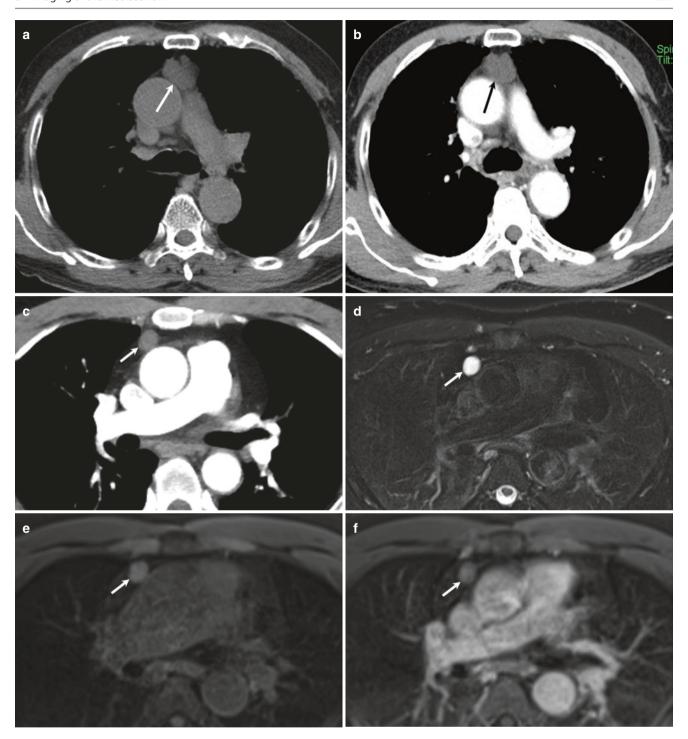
(a, b) Unenhanced and contrast-enhanced CT images show a thymic cyst (arrow) in typical prevascular space location without any enhancement. High-density thymic cyst in another patient. (c) Axial CT image shows a small well-marginated nodule
